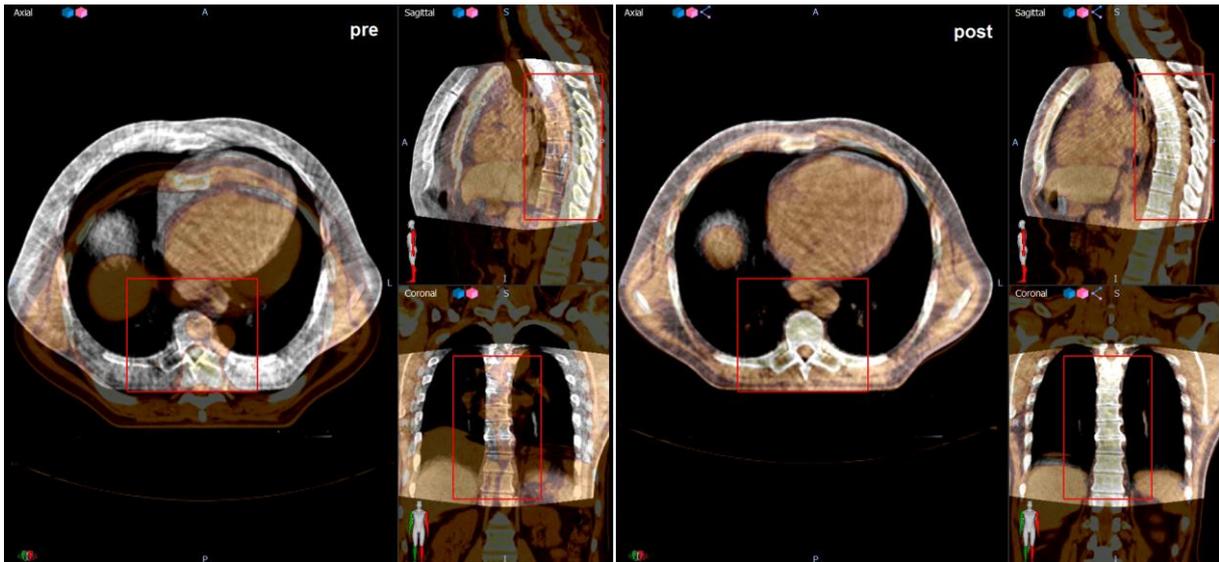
The pCT and CBCT before (left) and after (right) bony anatomy registration. The pCT is orange, the CBCT is grey. The red box placed over the spine is the region of interest used by the auto-registration algorithm.
